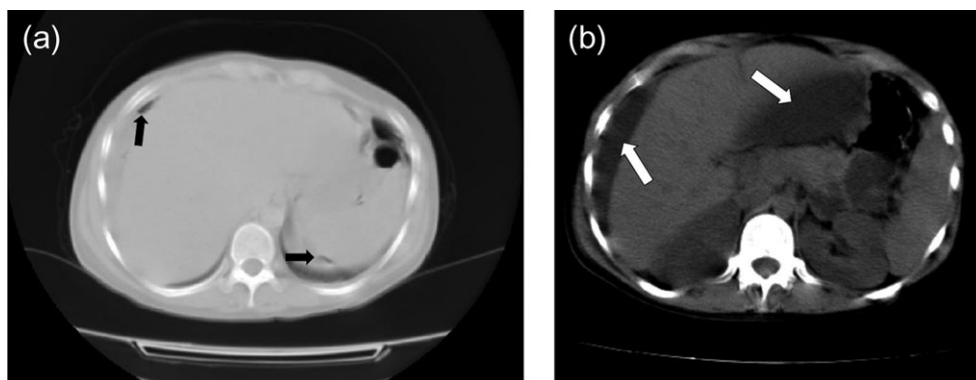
(a) Abdominal CT scan showing pneumoperitoneum around the right hepatic lobe and around the spleen (black arrows). (b) Abdominal CT scan showing ascitic fluid within the peritoneal cavity (white arrows).
